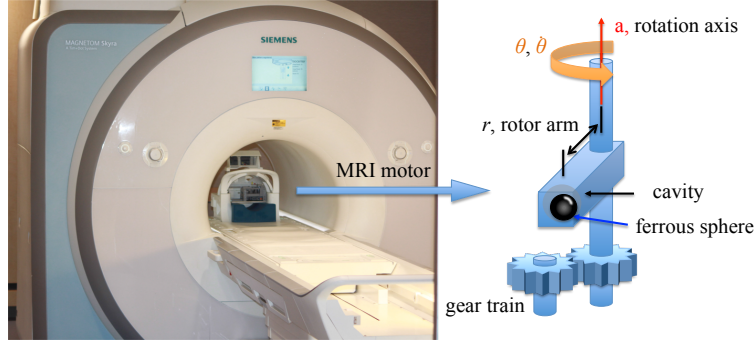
An MRI-powered motor inside a clinical scanner. Control of motor position and torque is enabled by interleaved imaging and actuating pulse sequences. These track motor angle and generate appropriate magnetic-gradient-based forces.
